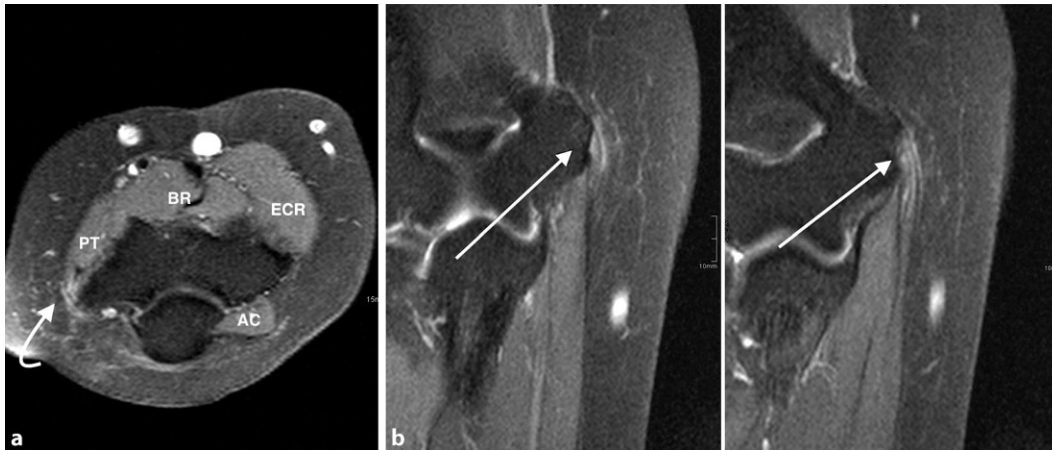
◀ magnetic resonance imaging of epicondylitis in axial (a) and coronary view (b). T1- and T2-weighted scans show signal difference in the area of the flexor tendons (white arrows); no sign of accompanying lesions of the medial collateral ligament or incongruency of the joint; pronator teres (PT), brachialis (BR), extensor carpi radialis (ECR), anconeus (AC)
